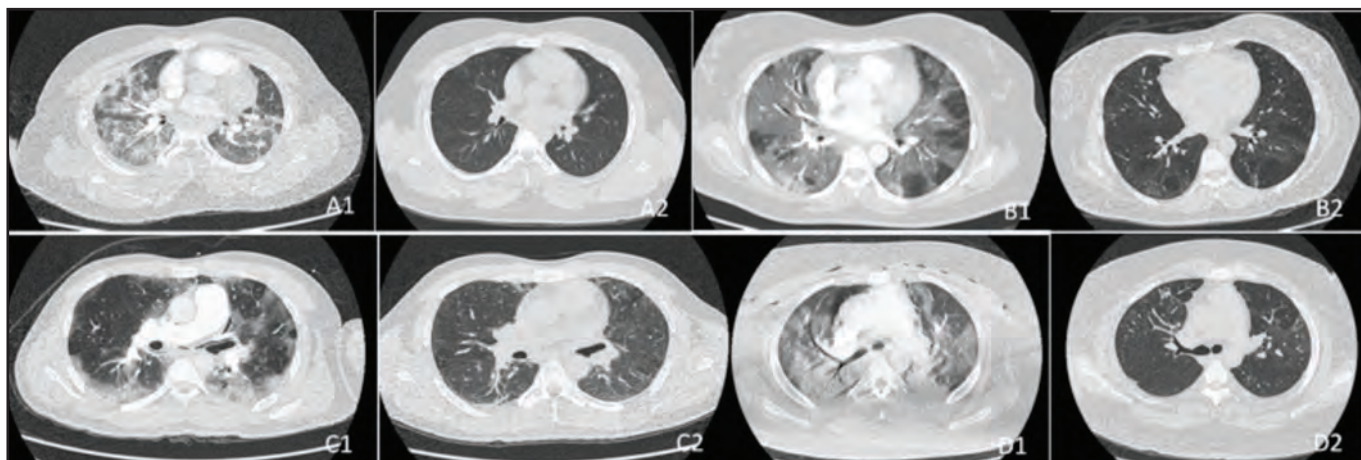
Axial chest HRCTs suggest a significant improvement in CT scores after CS therapy. (A1) Pre-CS: consolidation and perilobular density of RML, RLL, and LLL. (A2) Post-CS: minimal linear parenchymal bands. Reduction of CT score, consolidations and perilobular density. (B1) Pre-CS: extensive GGO and the arcade-like all lobes. (B2) Post-CS: residual GGO and linear parenchymal bands. Reduction of CT score and GGO. (C1) Pre-CS: peripheral consolidation and GGO of all lobes. (C2) Post-CS: GGO and reticulation. Reduction of CT score, consolidations and GGO. (D1) Pre-CS: extensive consolidation of all the lobes, pneumomediastinum and subcutaneous emphysema. (D2) Post-CS: complete regression of consolidations and pneumomediastinum with residual reticulation. Reduction of CT score and resolution of consolidation and pneumomediastinum.
